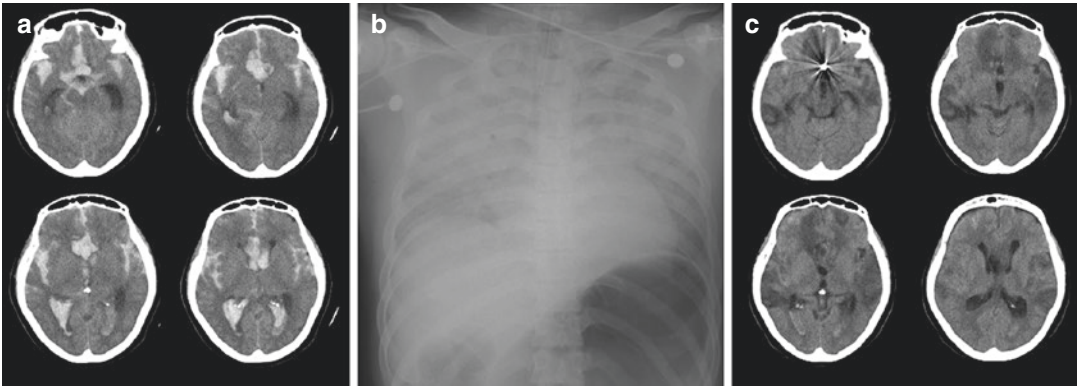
(a) A 52-year-old male presents with deep stuporous mental status. The initial brain computed tomography (CT) shows subarachnoid hemorrhage with overt intraventricular hemorrhage. (b) The initial chest X-ray demonstrates neurogenic pulmonary edema with diffuse
